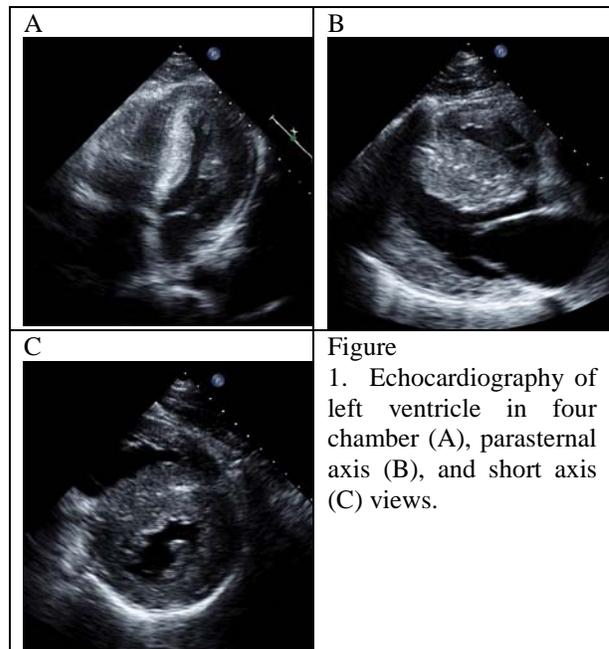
Echocardiography of left ventricle in four chamber (A), parasternal axis (B), and short axis (C) views.
